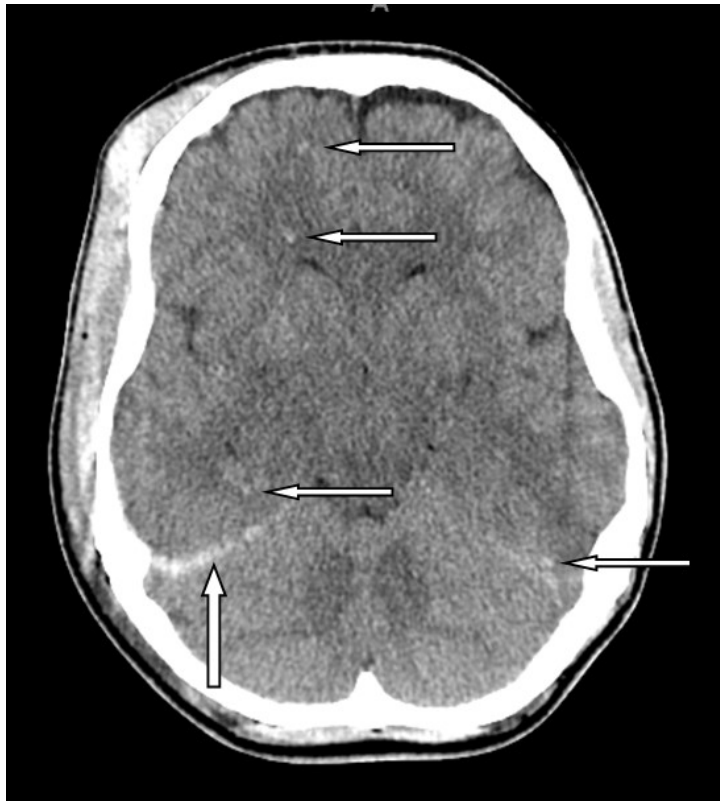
Figure (iii) Axial CT dated 1 July 2021. Multiple microhaemorrhages within the brain are marked with horizontal arrows. A thin subdural haematoma beneath the tentorium is marked with the vertical arrow.
